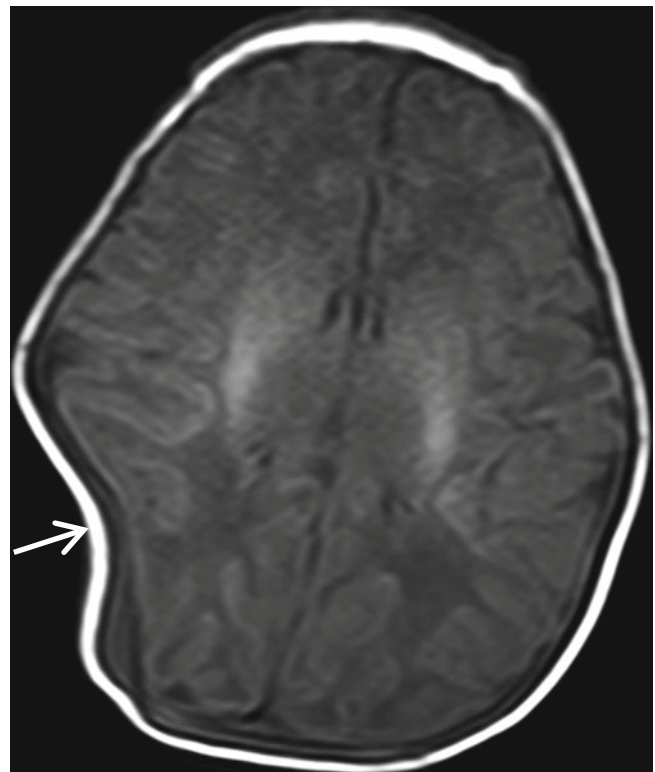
Depressed skull fracture after forceps delivery. T1-weighted axial image shows depressed outer contour of the right temporo-occipital bone (arrow)
